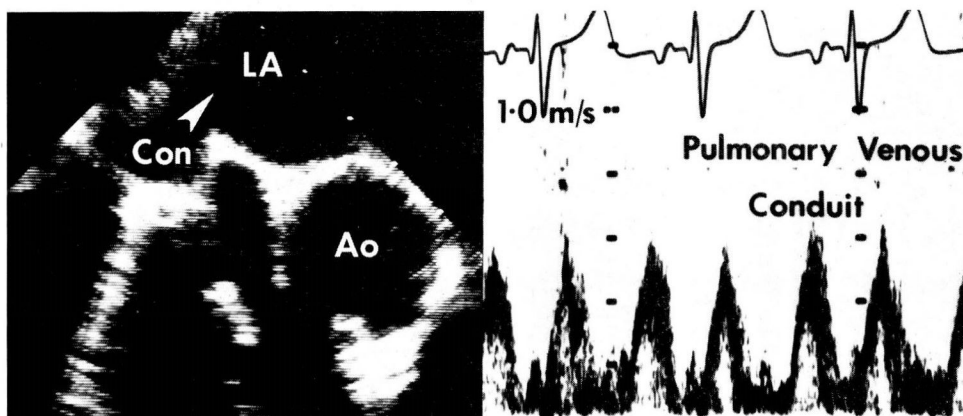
Case 1. Postoperative transesophageal echocardiography shows patency of the conduit repair with a normal pulmonary venous flow.
